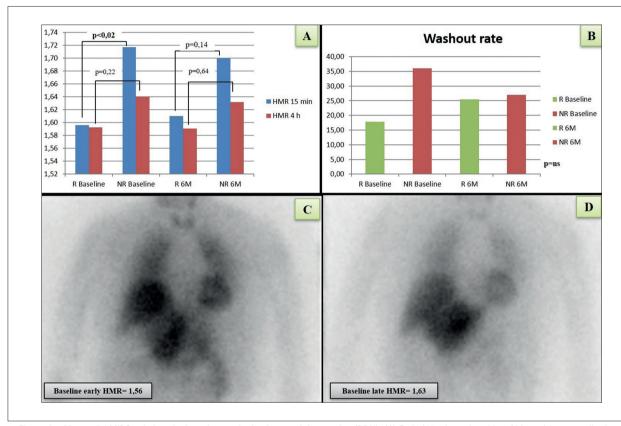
Myocardial MIBG scintigraphy in patients submitted to renal denervation (RDN). (A) Early (15 minutes) and late (4 hours) heart-mediastinum ratio (HMR) at baseline and six-months (6M) after RDN, in 'responders' (R) vs 'non-responders' (NR) – early HMR was significantly lower in R, at baseline; (B) Washout rate at baseline and six-months after RDN in R vs NR; (C) and (D) MIBG scintigraphy, thorax anterior projection, at baseline, in a responder, at 15 minutes (C) and at four hours (D).
